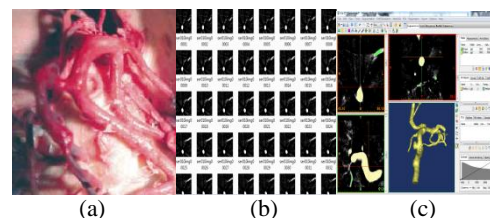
The cerebral aneurysms reconstruction. (a) blood vessel with aneurysms, (b) CT images, and (c) reconstructed model in MRS.
